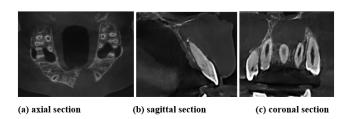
CBCT scan showing A well-defined round unilocular radiolucency seen at the apex of 21,22. Buccal cortical plate expansion was seen.
